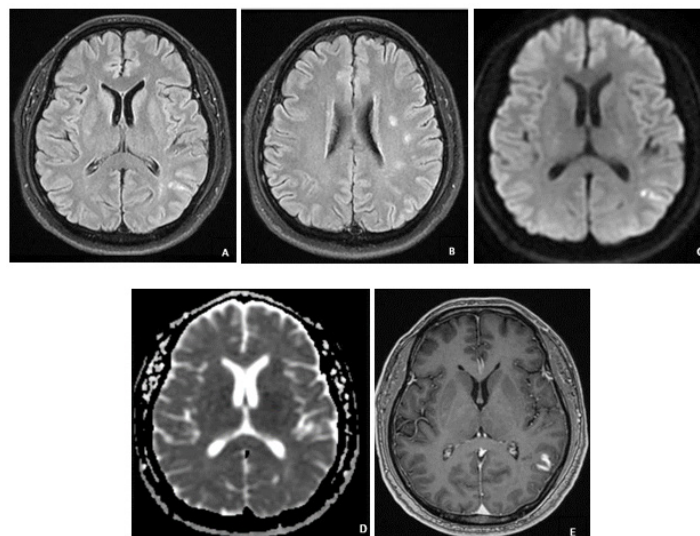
MRI brain showed hyper SI at the left parietal cortex on axial FLAIR FS image(A) without restrict diffusion on axial DWI (C) and ADC (D) images. Axial 3D T1W post gadolinium administration showed gyral enhancement at this region (E). Lacunar infarctions at corona radiata of the left frontoparietal region were present on the axial FLAIR FS image (B). (front cover)
